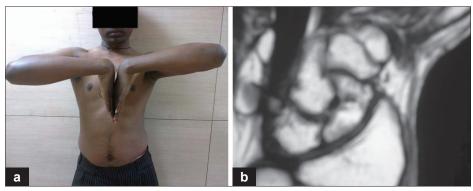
(a) Clinical photograph at 2 years showing range of motion (b) MRI scan after 2 years showing evidence of revascularization
